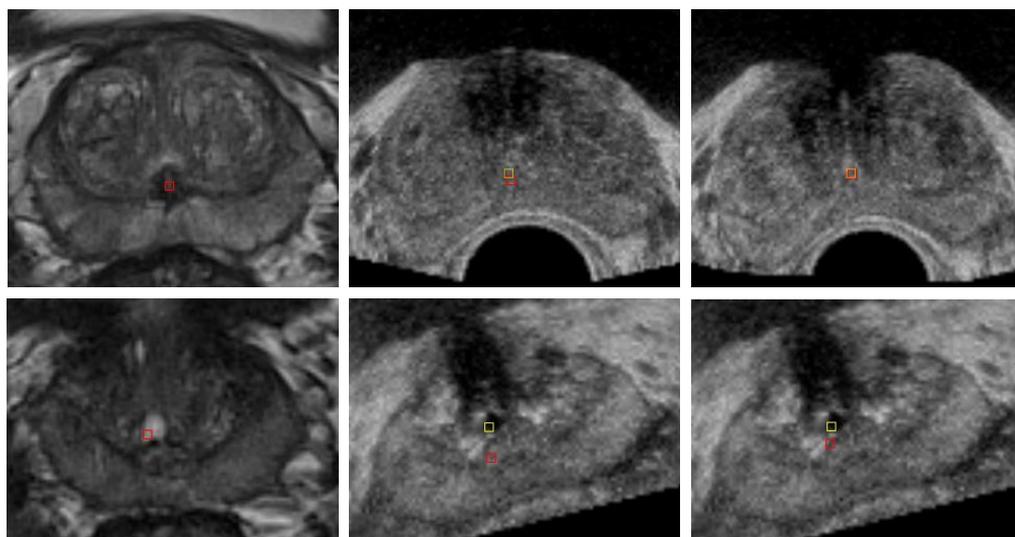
Examples from two different patients showing the real and registered positions of reference landmarks. Each of the two rows contains corresponding MR and TRUS images of the prostate of one patient. The left column shows the prostate MR image with an internal anatomical prostate landmark in red. The middle and right images show the corresponding prostate TRUS images of that patient where the yellow squares indicate the real positions of the reference landmarks and the red squares indicate the registered positions. The middle column shows the results of the regular non-rigid surface-based registration method and the right column of the biomechanical constrained registration method. Both cases show that the biomechanical model decreased the distance between the yellow and red squares (the TRE) and thus improved the registration accuracy. The example in the top row has a more accurate registration accuracy than the example in the bottom row for both registration methods.
